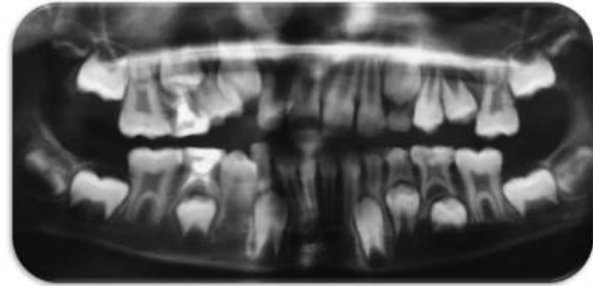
Panoramic radiograph of Case 1.
